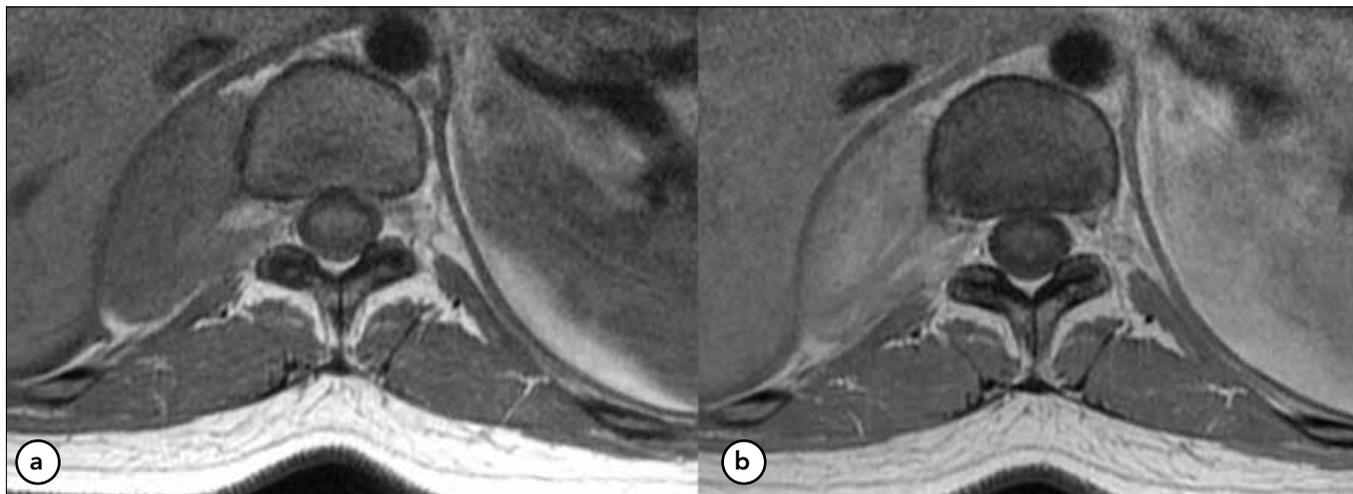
On precontrast (2A) and postcontrast (2B) T1-weighted MR images, prominent contrast enhancement of the mass extending towards the neural foramen is clearly visible
